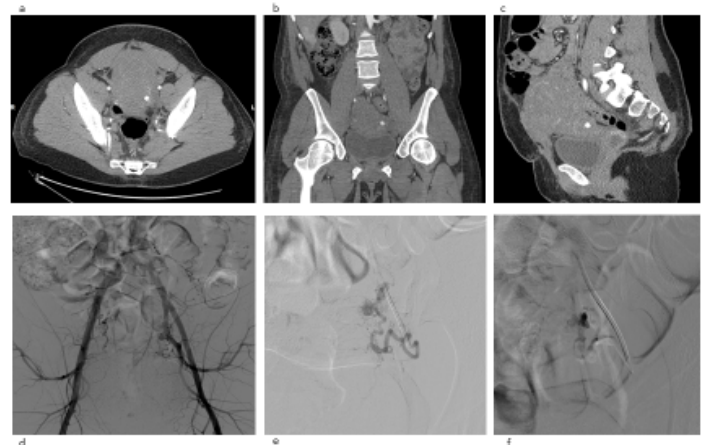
A. Axial computed tomography angiography shows focus of arterial enhancement/ contrast-filled pseudoaneurysm along the left uterine body B-C. Coronal and Sagittal reconstructed contrast-enhanced CT scan shows the contrast-filled pseudoaneurysm of the left uterine artery. D Pelvic angiogram and E. Selective left internal iliac angiograms show the pseudoaneurysm arising from the left uterine artery. F. IR-guided embolization of the pseudoaneurysm and left uterine artery using gelfoam.
